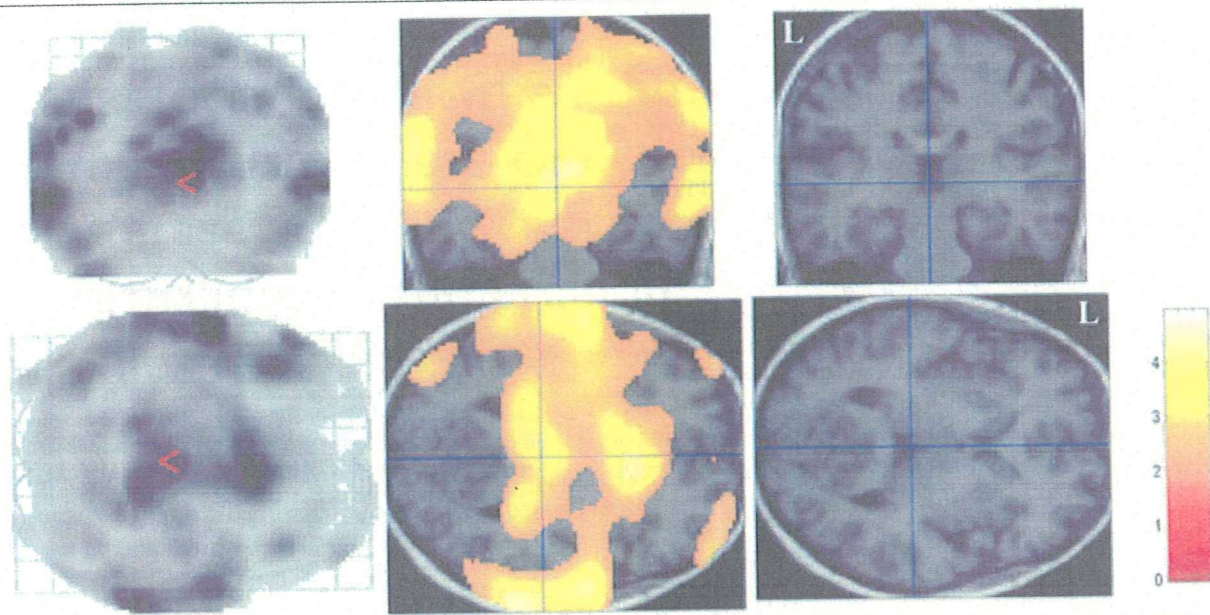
Brain areas with a significant decrease of [ $^{123}\text{I}$ ]5-I-A-85380 distribution volume ( $V$ ) in Parkinson's disease patients detected with a two-sample  $t$  test in Statistical Parametric Mapping version '02. Areas with a significant decrease are displayed in the glass brain (left) and on transverse and coronal slices through thalamus of a magnetic resonance (MR) image of a control subject (middle). Corresponding MR images without superimposition are shown on the right. Highlighted areas showed  $p$  less than 0.05 false-discovery rate, which was corrected for multiple comparisons. The area also showed cluster-level corrected  $p$  less than 0.001. Color bar shows  $T$  values with the maximum value of 4.96. Note that the glass brain view displays decreases in the entire brain superimposed to anteroposterior (top left) or top-bottom (bottom left) views, whereas the MR images with the superimposition display decreases on single slices.
